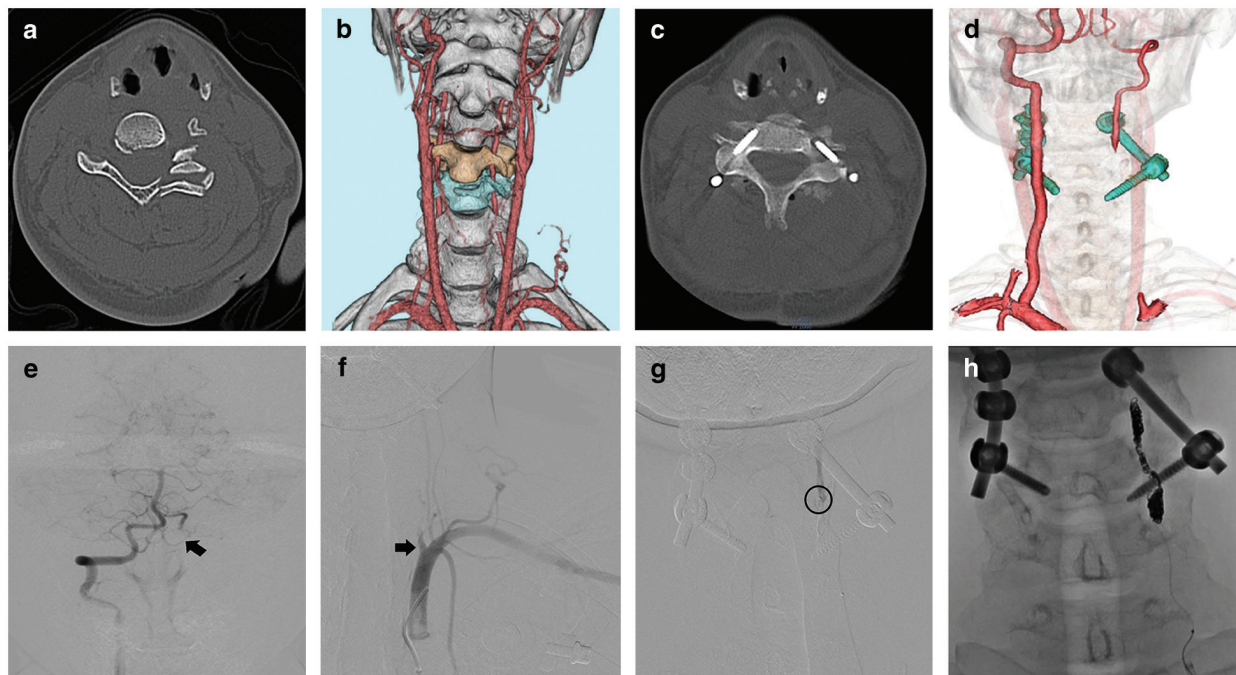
(a) CT scan of the cervical spine showing a dislocation fracture at the C4–C5 level. (b) Preoperative CT angiogram showing no bilateral VA injuries. (c) Postoperative CT scan showing a left C4 pedicle screw perforating the transverse foramen. (d) Postoperative CT angiogram showing no visualization of the left VA from the origin to the distal side of the screw. (e) Right VA angiogram showing the left posterior inferior cerebellar artery retrogradely (arrow). (f) Left subclavian artery angiogram showing the left VA suspected to be occluded at the origin (arrow). (g) The microcatheter could be navigated distal to the screw through the ipsilateral approach without much resistance. Circle, position of the microcatheter tip. (h) Coil embolization. CT: computed tomography, VA: vertebral artery.
